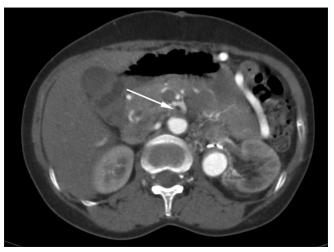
Computed tomography angiogram showing occlusion of superior mesenteric artery (arrow)
